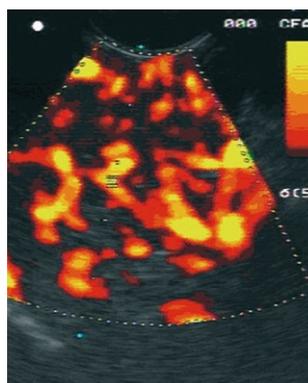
Contrast enhanced endoscopic ultrasound image using SonoVue injection of a focal pancreatic lesion. The region shows regular vascularization consistent with chronic pancreatitis. Image courtesy of Hocke M *et al*, *World J Gastroenterol* 2006^[24].
